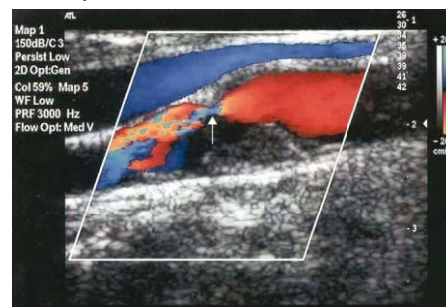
Duplex doppler ultrasound showing severe stenosis (Naylor 2007).
